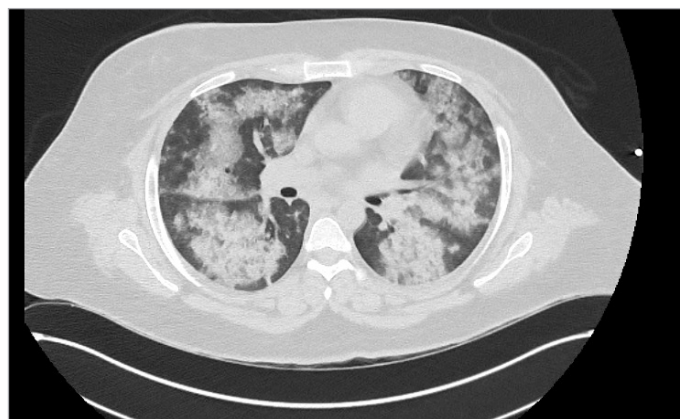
CT Thorax 18/12.
